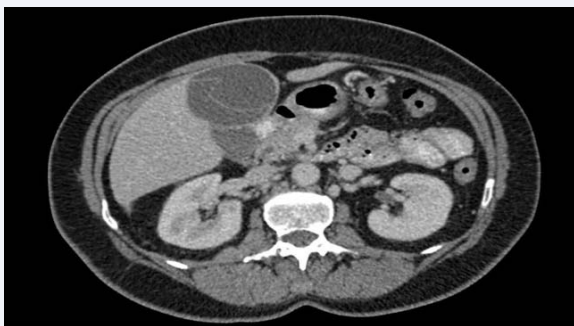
CT imaging Hydatid cyst communicates with gall bladder.
